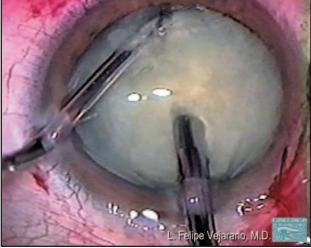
The irrigating chopper is moved inside the capsular bag, along the lens equator, and placed in front of the phaco tip. At that moment additional pulsed ultrasound is applied, so that the tip buries deeper into the nucleus, before the chopping is started.
